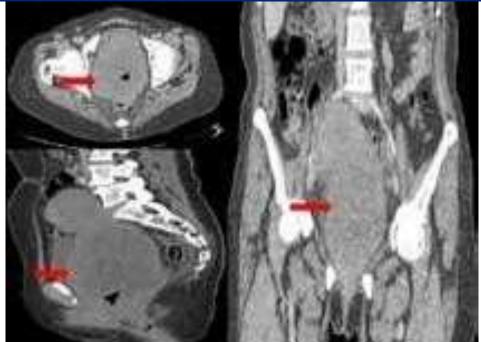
Axial section of a pelvic CT scan with reconstruction in the coronal and sagittal planes showing a bilobed mass centered in the uterus, containing calcifications. The mass is well bounded and displaces the bladder frontally and the sigmoid posteriorly.
